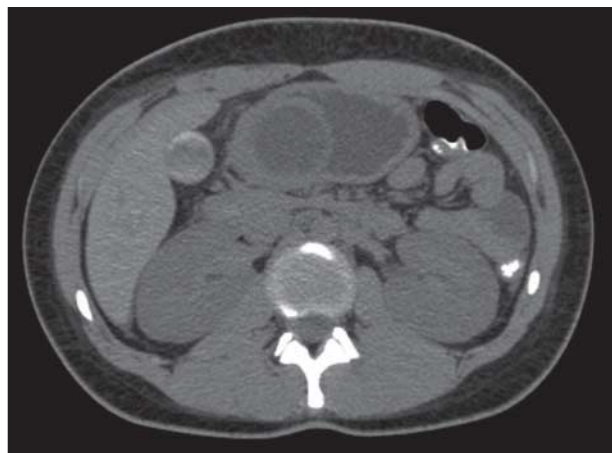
Abdominal computed tomographic scan demonstrating cystic structure in the antrum of the stomach, with dilatation of the gastric lumen.
